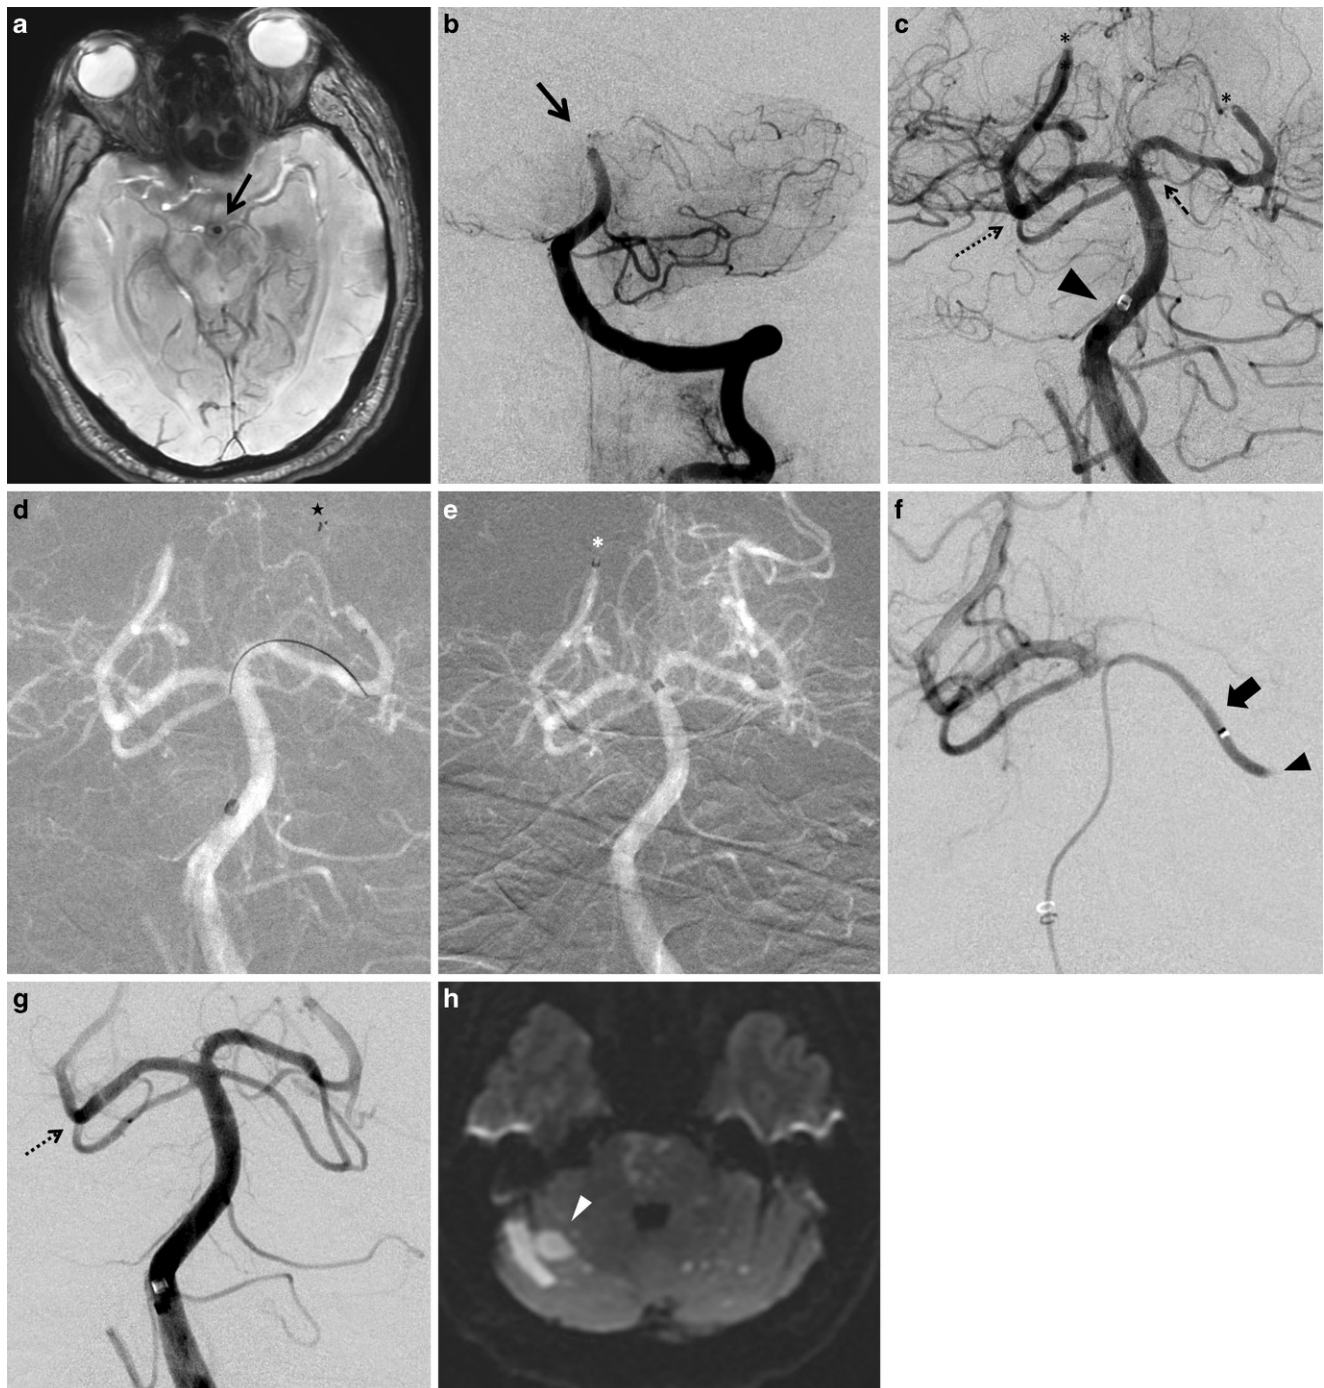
A 67-year-old man with sudden onset of coma (National Institute of Health Stroke Scale [NIHSS] 28). a Axial susceptibility-weighted magnetic resonance images showing signal void inside the distal basilar artery assessing the presence of the clot which was confirmed by the MR angiography and during perprocedural selective left vertebral artery DSA (Digital Subtraction Angiography) (b, *black arrow*). c DSA through the ACE64 (*black arrow head*): clot fragmentation caused by the initial road map injection for catheter navigation is demonstrated: bilateral posterior cerebral artery (PCA) occlusions (P3, *black asterisks*) and bilateral superior cerebellar artery (SCA) occlusions (First segment on the left side and second segment on the right side [*dotted arrows*]) are seen. d Road map in anteroposterior (AP) projection. After two failed thromboaspiration attempts with the 3MAX, recanalization of the left PCA was obtained with a stent retriever (4/20 mm Solitaire Flow Restoration; *black asterisk*) (Thrombolysis In Cerebral Infarction [TICI] 3 recanalization). e Road map in AP projection: direct thromboaspiration through the 3MAX is successfully performed on the right PCA occlusion (*white asterisk*). f Selective DSA through a Velocity 2.6F delivery microcatheter (*large arrow*) (Penumbra) placed into the left SCA after a failed 3MAX navigation attempt, showing occlusion of the left SCA (*black arrowhead*). TICI 3 was obtained after the second stent-retrieving attempt with a Solitaire. g Control DSA in AP projection: TICI 3 recanalization of both PCAs and left SCA. Partial spontaneous recanalization of the right SCA during the procedure is also seen (*dotted arrow*). h Axial diffusion weighted images at day 1 after MT: multiple punctuate infarcts as well as an infarct in the right SCA territory are seen (*lateral branches*; *white arrowhead*)
